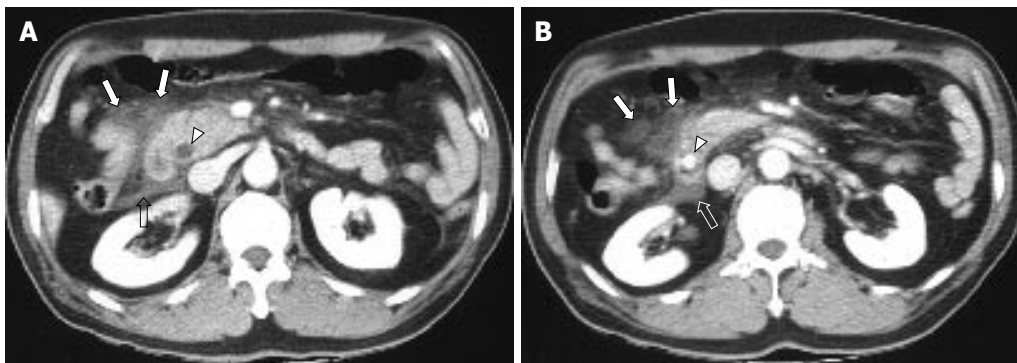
A 61-year old man with a clinical diagnosis of gallstone pancreatitis due to distal common bile duct stone. A and B: CT scans showing the peripancreatic infiltration or fluid collection predominantly in the right abdomen: score 1 infiltration in RP compartment (arrows), score 2 fluid collection in RSR compartment (open arrows). Distal common bile duct stone with bile duct dilatation also can be seen (arrowheads).
